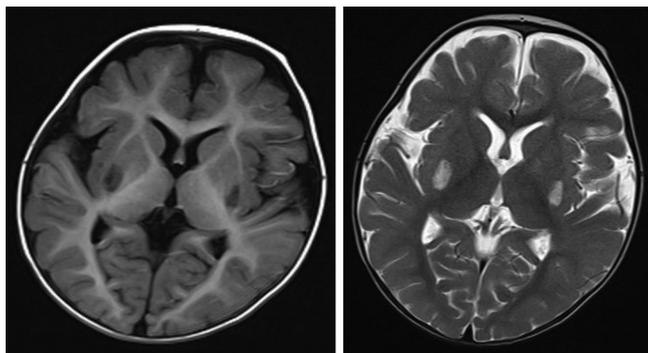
MRI brain showing bilateral symmetric altered signal intensity in basal ganglia, cerebellar and cerebral peduncles and medulla.
